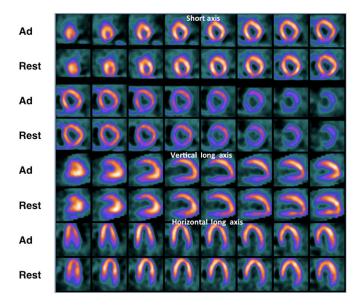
Adenosine stress and rest perfusion images of a 48-year-old male with long history of hypertension, heavy alcohol abuse, smoking, and atrial fibrillation. He was admitted with worsening heart failure after an alcohol binge. After initial stabilization, he underwent adenosine and rest perfusion imaging. He has no chest pain or ST depression. There is no perfusion abnormality. But the LV is markedly enlarged, hypertrophied, and severely hypokinetic on gated SPECT images with an ejection fraction of 28%. This patient has nonischemic cardiomyopathy.
